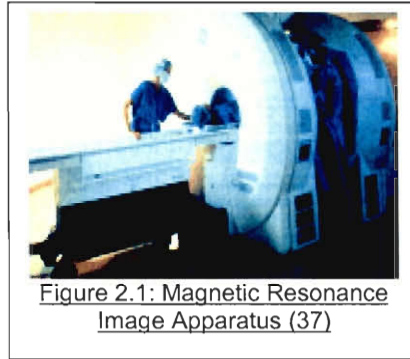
Magnetic Resonance Image Apparatus (37)
